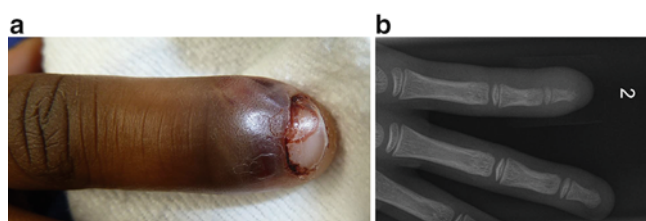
(a) Paronychia of index finger and (b) associated osteomyelitis of distal tuft on radiograph
